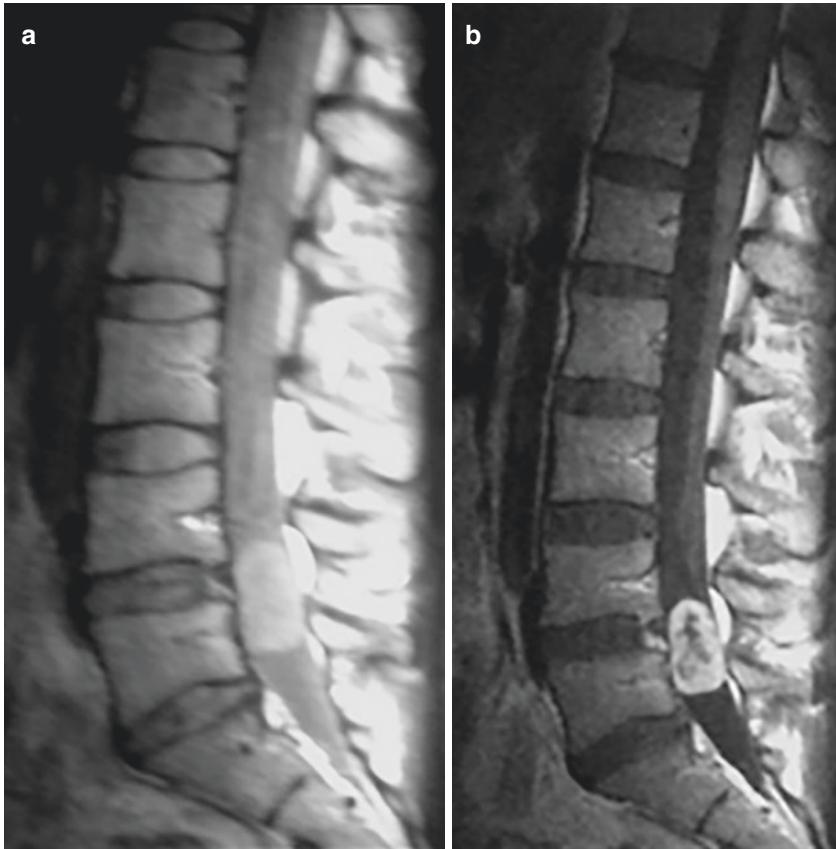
Myxopapillary ependymoma in 29-year-old female with a history of mild lower-back pain. Sagittal proton-density (PD) weighted (a), and contrast-enhanced T1-weighted (b) image demonstrating well-define hyperintense cauda equina mass on proton-density (PD) weighted image, heterogeneously enhanced
